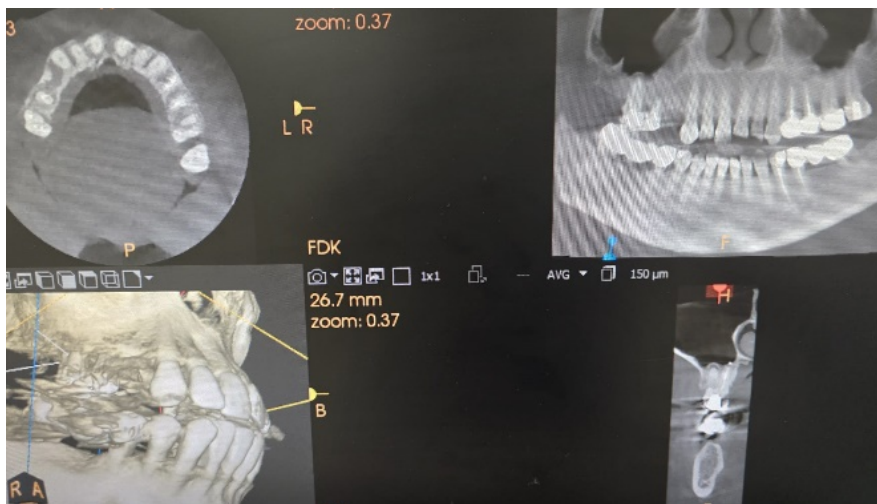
The initial CBCT.
